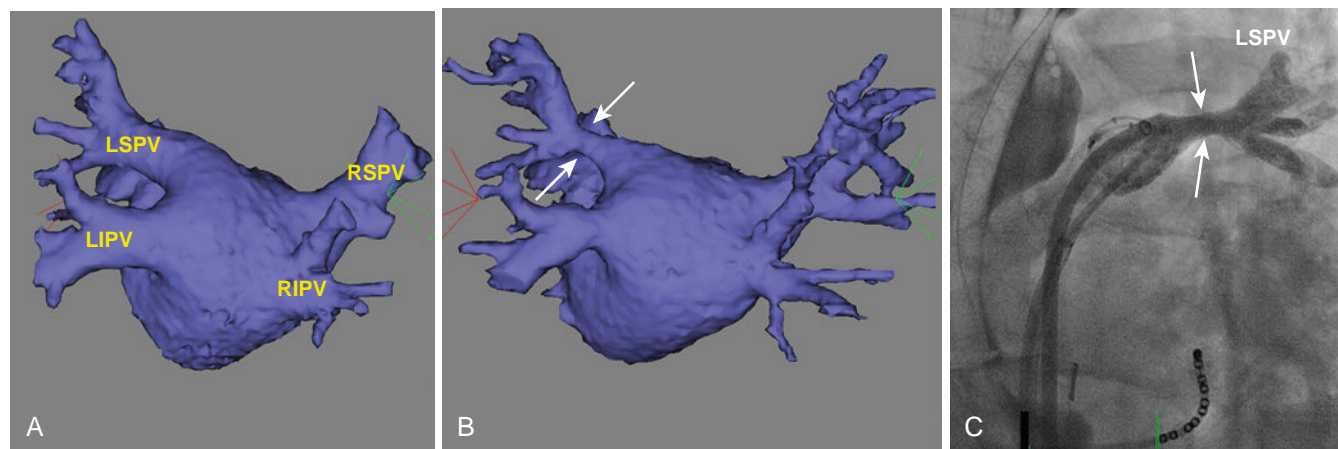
Pulmonary Vein (PV) Stenosis. (A) Computed tomography (CT) image of the left atrium and PVs at baseline before segmental ostial PV isolation. (B) CT image 3 months after the ablation procedure, showing moderate stenosis of the left superior PV (LSPV; arrows) and mild stenosis of the left inferior PV (LIPV). (C) Angiogram (left anterior oblique view) of the LSPV, showing a moderate degree of stenosis (arrows). RIPV, Right inferior PV; RSPV, right superior PV.
